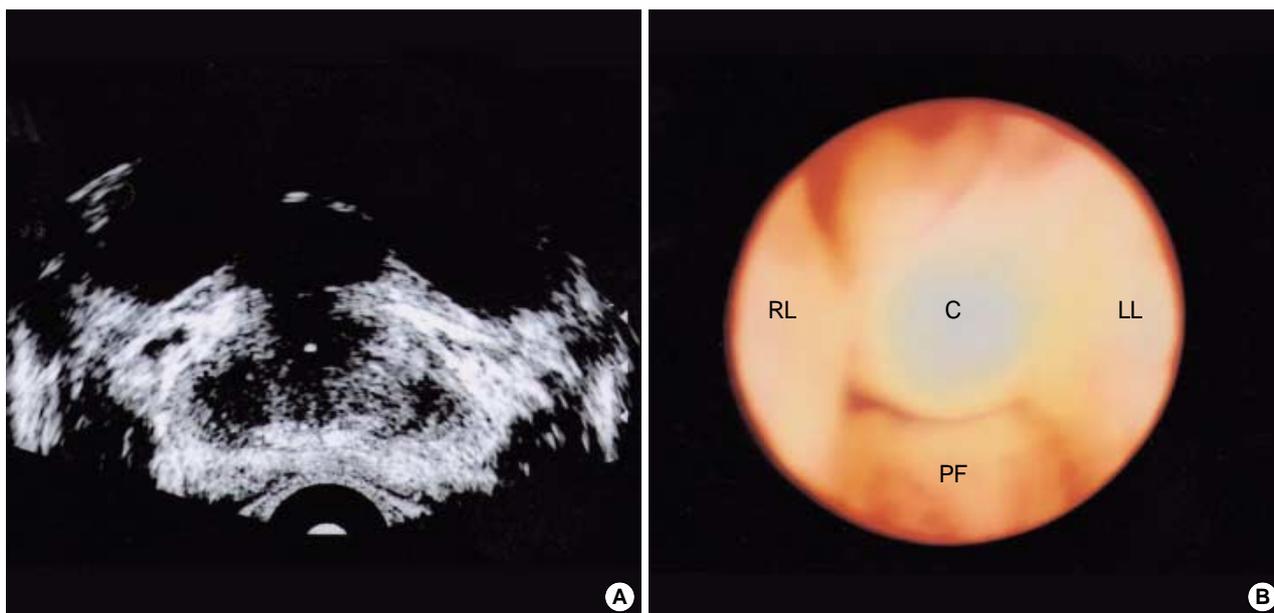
(A) Basal portion of the urinary bladder near the bladder neck reveals a 20 × 15 mm sized cystic lesion on transrectal ultrasound. (B) The cyst with smooth surface is located at the bladder neck and there is a crescent-shaped narrow space noted on cystoscopy. RL: right lateral lobe; LL: left lateral lobe; C: cyst; PF: prostate floor.
